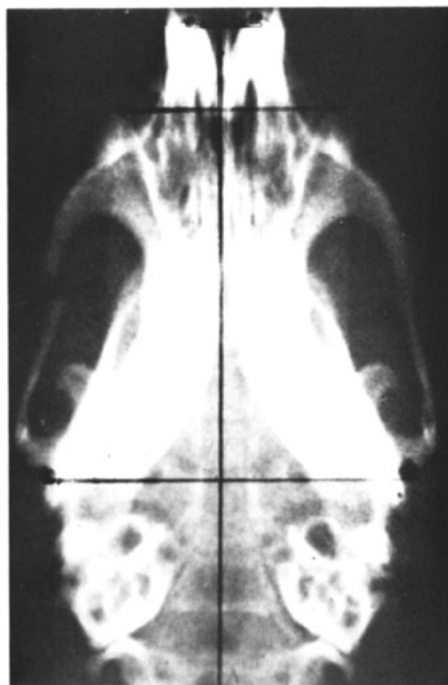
Construction of tracing for analysis, superimposed on X-ray film.
